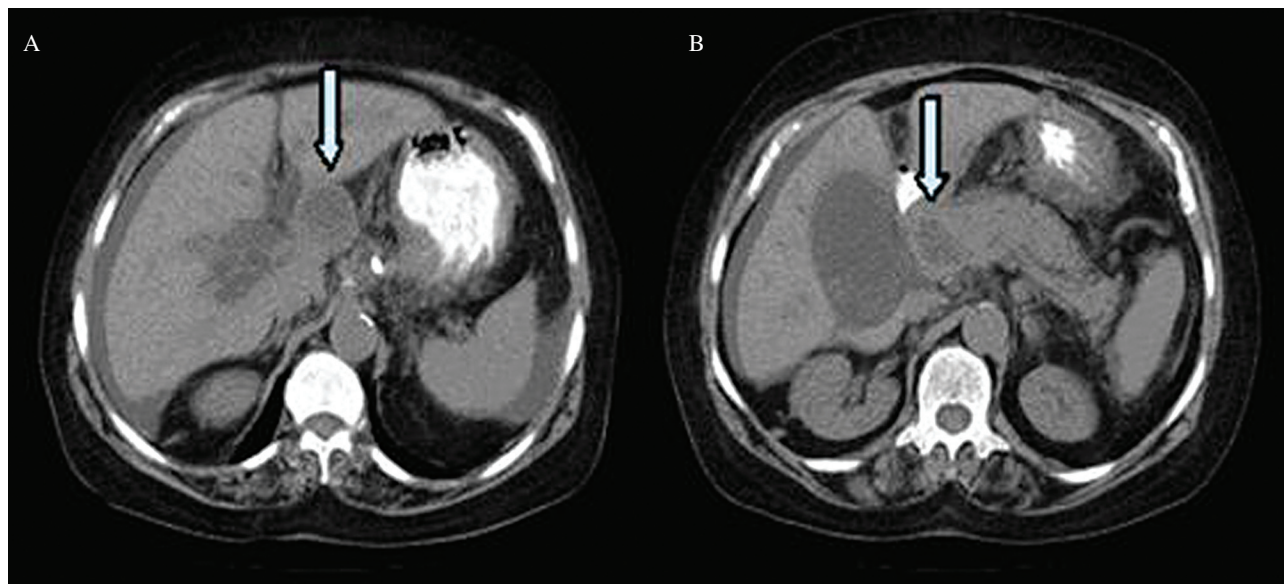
Abdominal CT images without contrast showing hydropic gallbladder, dilated bile ducts and choledochus, minimal thickening of the mesentery due to inflammation, and cystic lesions in the head of the pancreas: (A) superior, (B) inferior.
